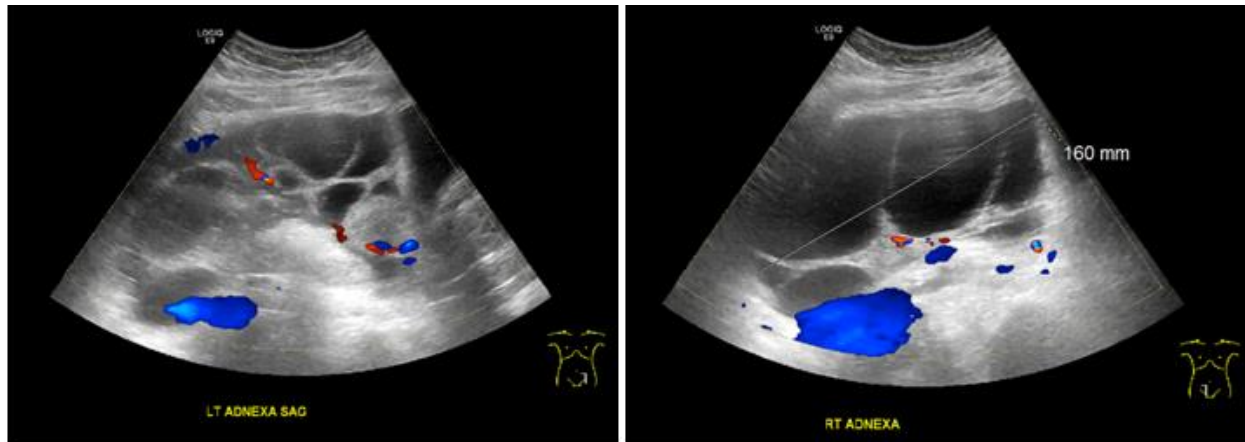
Abdominal ultrasound on Hospital Day #4. Abdominal ultrasound revealed bilaterally enlarged ovaries, ascites, and bilateral pleural effusions. Left image is the left ovary (170 x 90 cm). Right image is the right ovary (160 x 100 cm).
